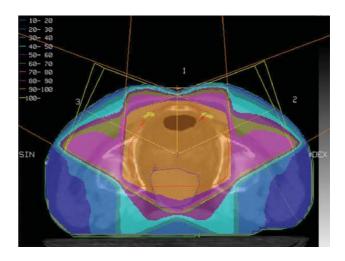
CT imaging of the PTV in locally advanced rectal cancer, treatment plan using direct posterior and posterior oblique fields).
